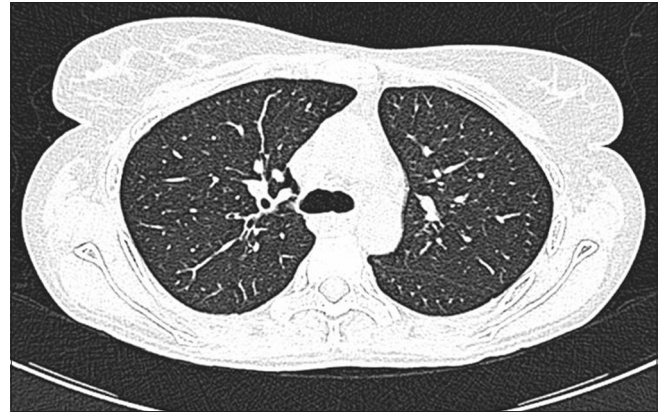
Normal HRCT scan
